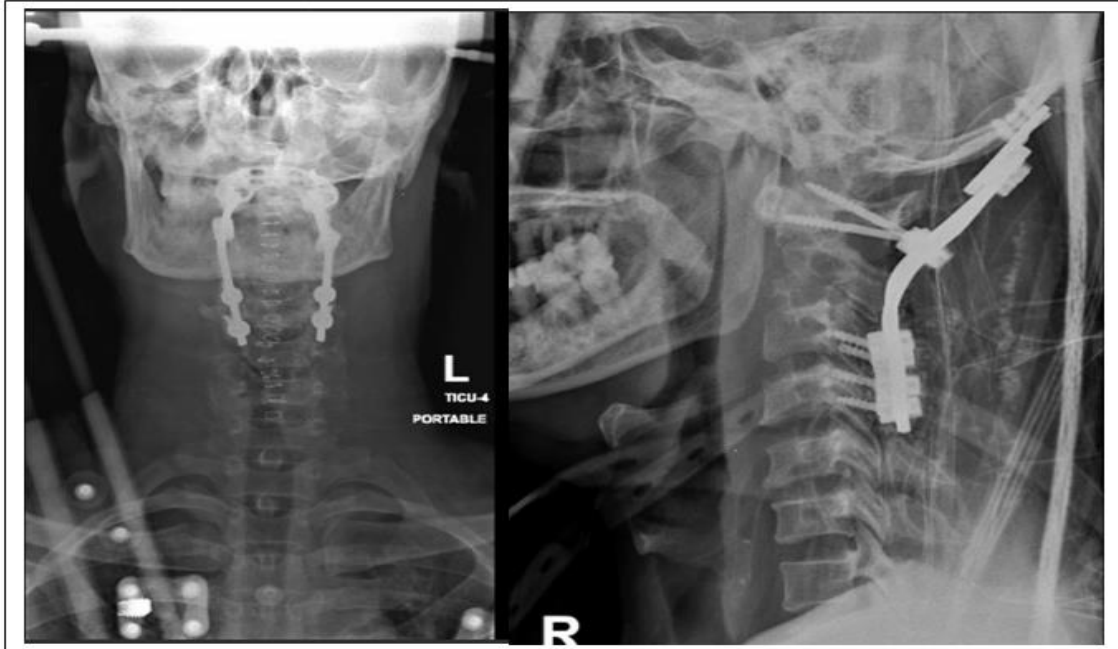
Post operative X-rays showing cervical spine fixation.
